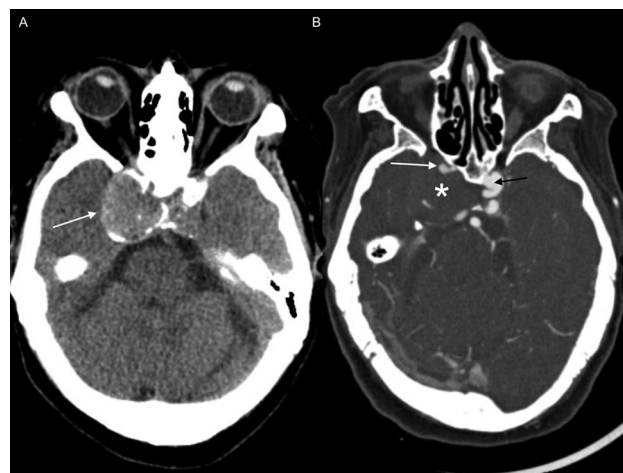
Unenhanced axial computed tomography (CT) scan (A) and CT angiography (B) showing a hyperdense mass adjacent to the right cavernous sinus with peripheral calcifications (arrow in A) and no enhancement (asterisk in B), opacification of the pervious internal carotid artery (white arrow in B), and a small contralateral aneurysm (black arrow).
